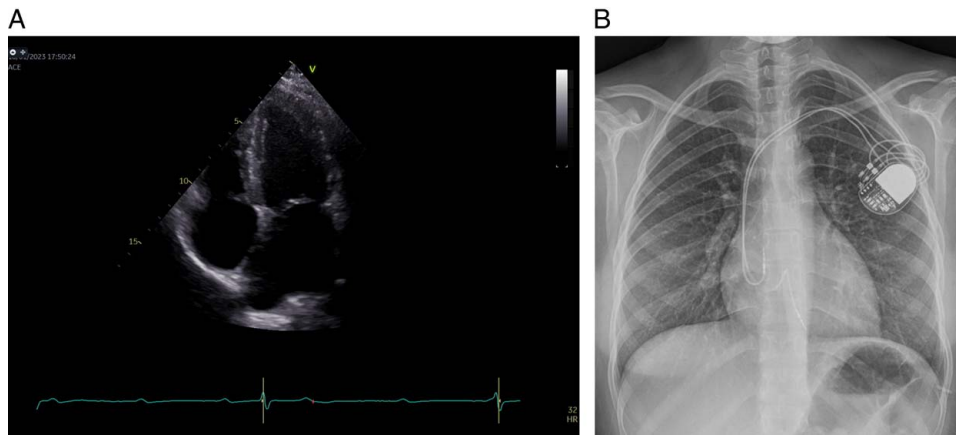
A. Normal echocardiography. B. Chest X-ray after permanent dual-chamber pacemaker implantation.
